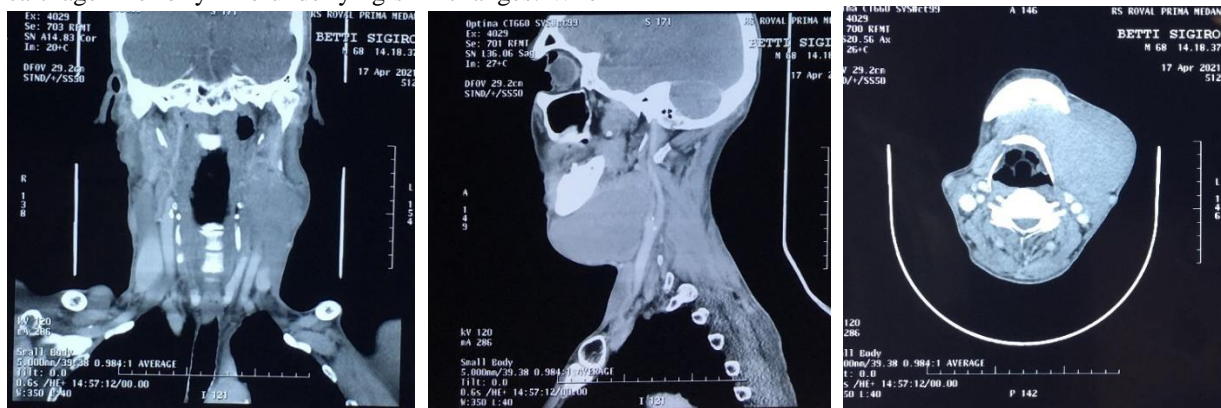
CT scan showing a well-defined isodense lesion measuring 9.7 x 6.3 x 6.2 cm, indistinguishable from the submandibular gland
